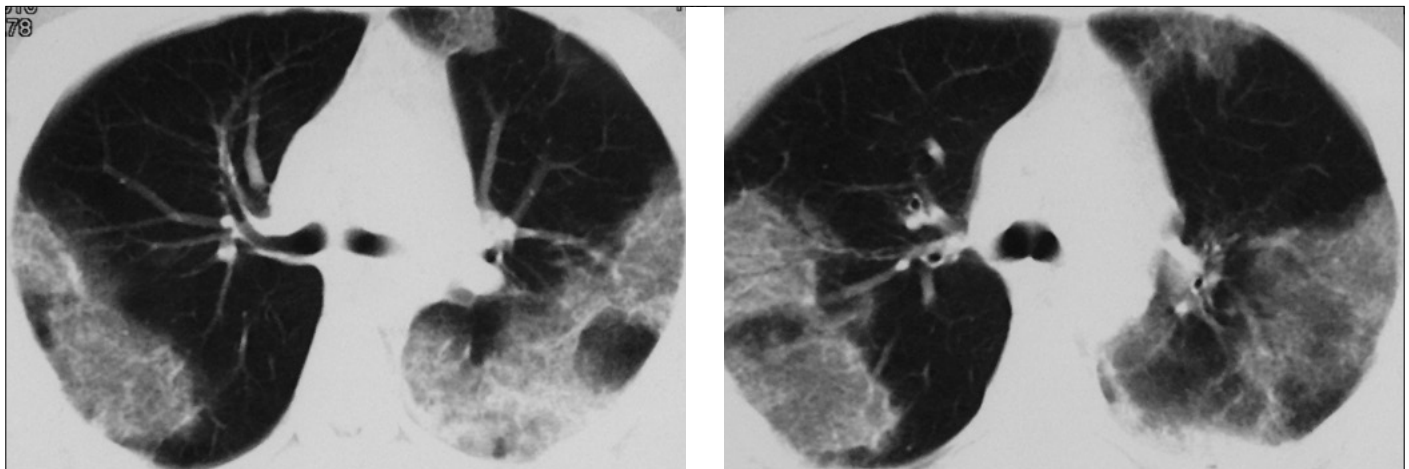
Case 13: A thorax CT image showing non-homogeneous bilateral diffuse infiltrates of peripheral localization with upper lobe predominance
